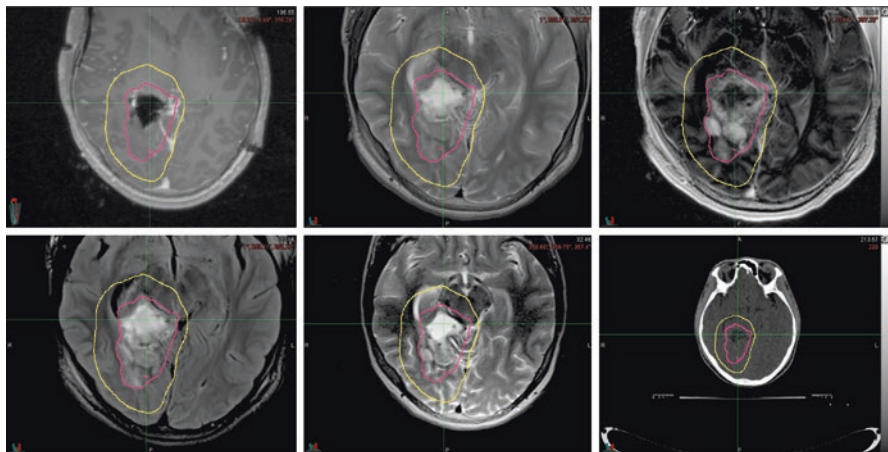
Postoperative treatment volumes. Top row, from right to left: T1 post-contrast, T2, T1 subtraction. Bottom row, from right to left: T2 flair, T2 fast spin echo, CT planning scan. Pink, gross tumor volume; yellow, clinical target volume
